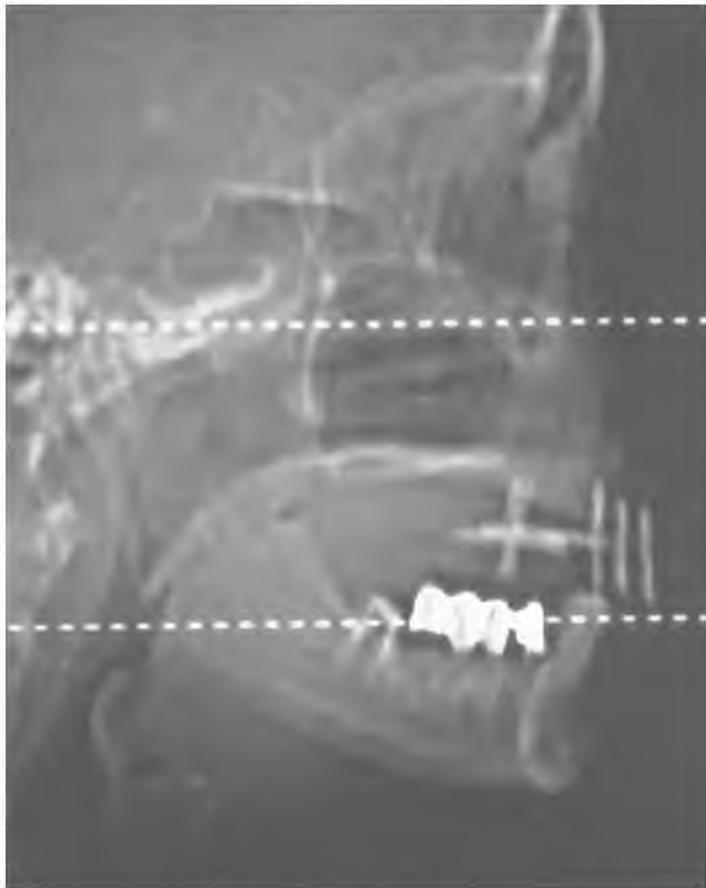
The first view taken by the CT scanner, the scout film, must show the radiopaque horizontal occlusal line parallel to the dotted perimeters.
